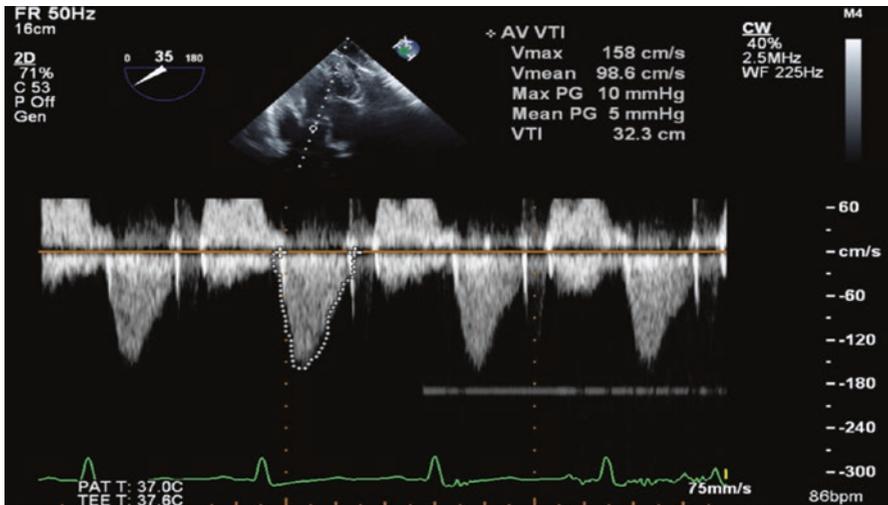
Continuous wave Doppler through the annulus of the aortic valve. V_{\max} = maximum velocity through aortic valve; V_{mean} = mean velocity at aortic valve; max PG = maximum pressure gradient at aortic valve; mean PG = mean pressure gradient at aortic valve; VTI = volume time integral at aortic valve
